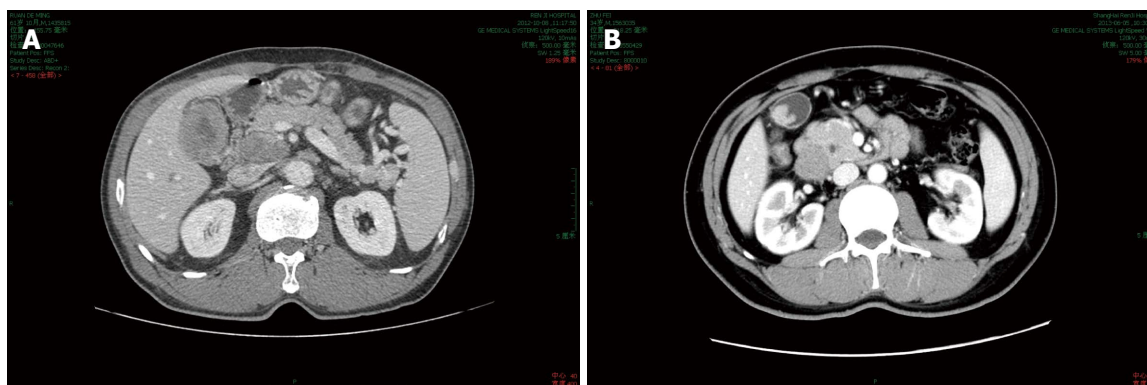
Computed tomography scan of the gallbladder carcinoma. A: A thick-walled gallbladder with local infiltration to the adjacent liver; B: A polypoid intraluminal lesion about 4 cm in diameter.
